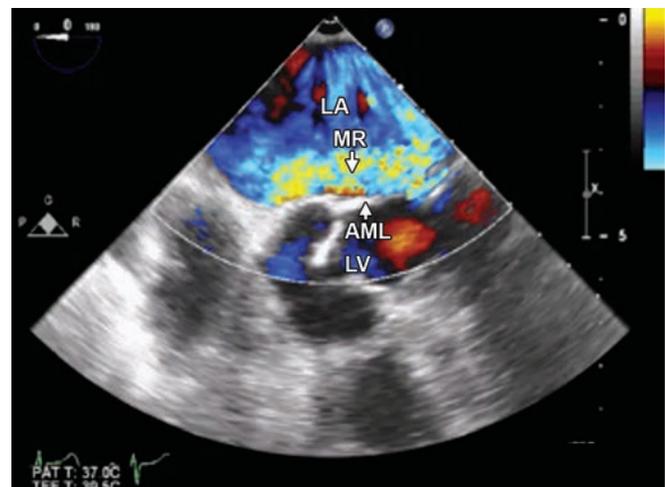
Two-dimensional transesophageal echocardiogram with color Doppler imaging at the mid-esophageal level showing severe mitral regurgitation with an anteriorly directed eccentric jet from posterior mitral leaflet prolapse.
